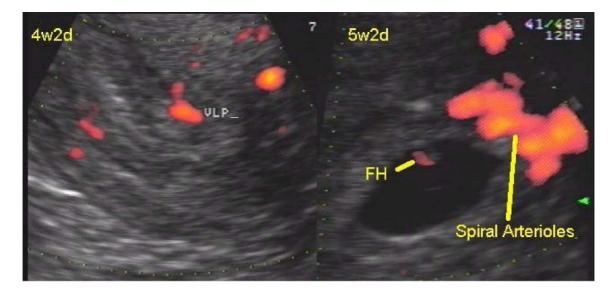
Power color Doppler imaging has enabled us to visualize the slowest placenta flow pattern as early as 4 weeks gestation. (VLP: vascular leading pole)
